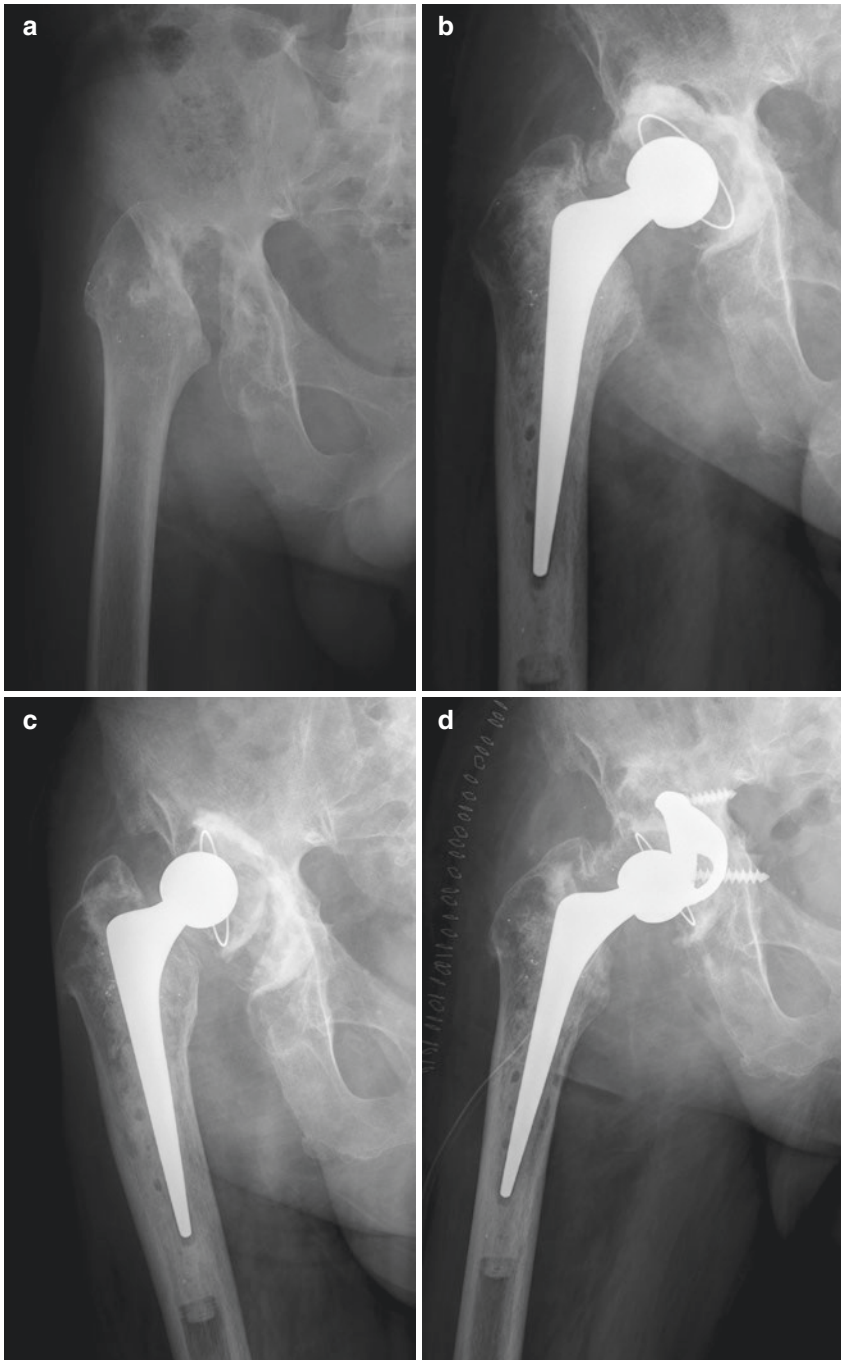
(a) preoperative radiograph shows a resection-arthroplasty after an infected total hip arthroplasty. (b) Impacting bone grafting was used in both components in revision surgery. (c) Postoperative radiograph. (d) Postoperative radiograph at 10 years shows symptomatic cup migration. (e) Impacting bone grafting associated with a tantalum augment was used in re-revision surgery
